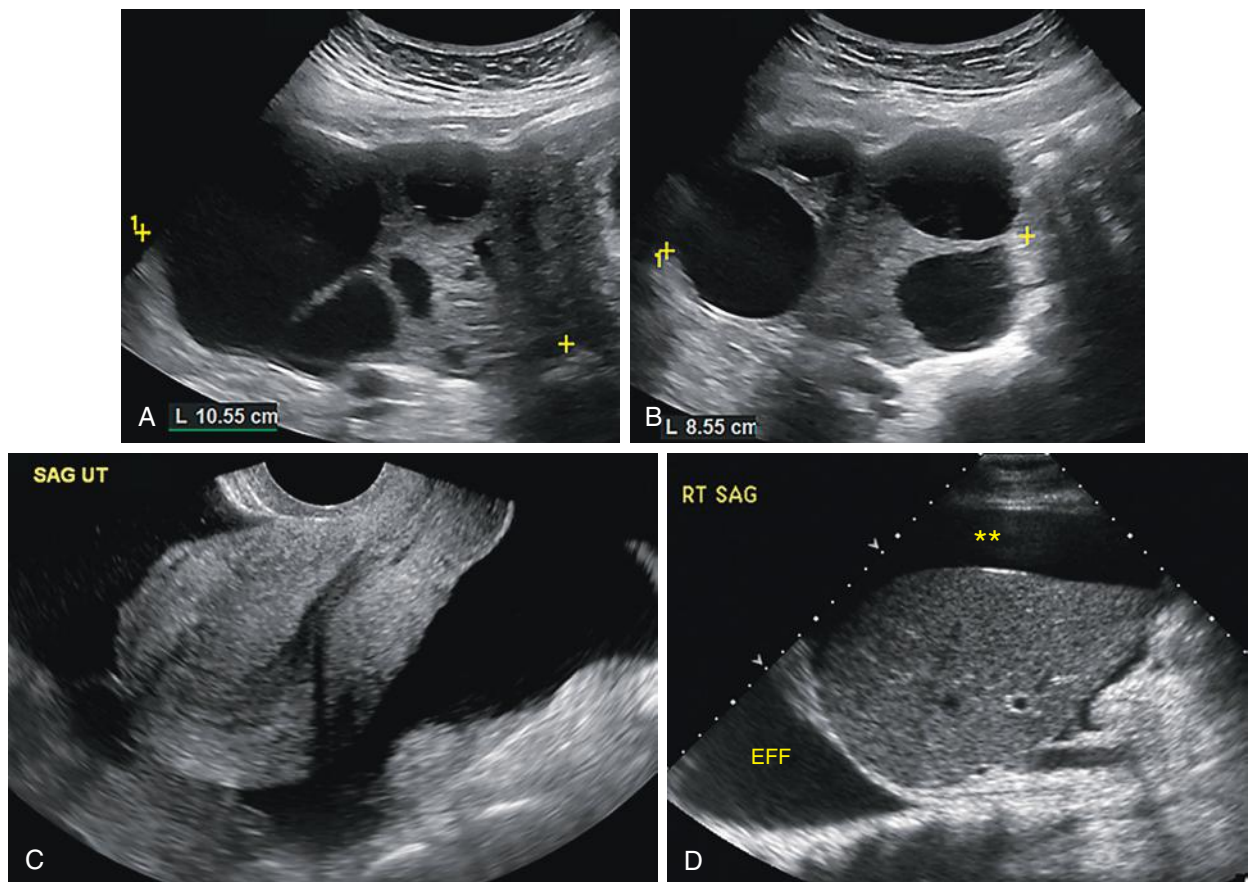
Ovarian hyperstimulation syndrome (OHSS), 2 weeks after oocyte retrieval. A, Sagittal transabdominal gray-scale image of the enlarged right ovary (*calipers*), which measures approximately 10.5 cm in diameter and contains multiple cysts. B, The enlarged left ovary measures approximately 8.5 cm in diameter and has a similar appearance, with multiple cysts shown on this transabdominal transaxial sonographic image. C, Sagittal transvaginal gray-scale image of the uterus shows a large amount of anechoic free fluid in the pelvis. D, Sagittal transabdominal gray-scale image of the right upper quadrant demonstrates free intraperitoneal fluid (*asterisks*) anterior to the right lobe of the liver and a right pleural effusion (EFF).
